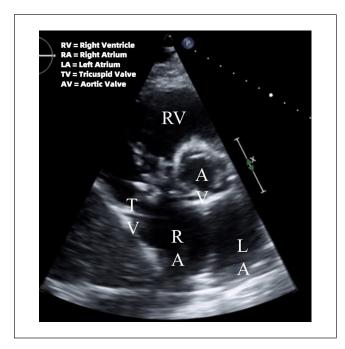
Transthoracic echocardiography showing vegetation attached to the tricuspid valve.
